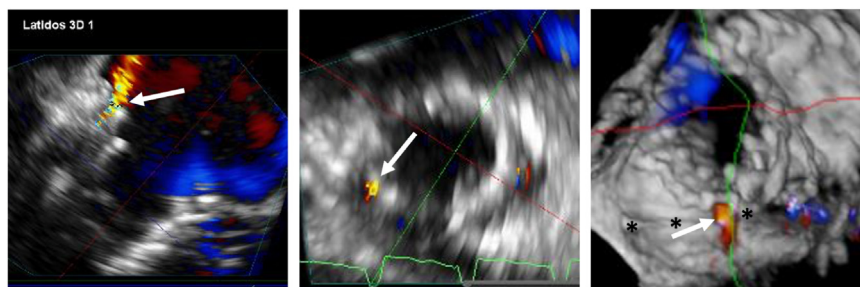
Three-dimensional echocardiography for TR quantification after transcatheter TV replacement in a severe lead-associated TR. After the implantation of an orthotopic Cardiovalve prosthesis, multiplanar reconstruction was useful to trace the residual jet (*arrow*) around the lead (*asterisks*), with a small VCA (<10 mm²).
